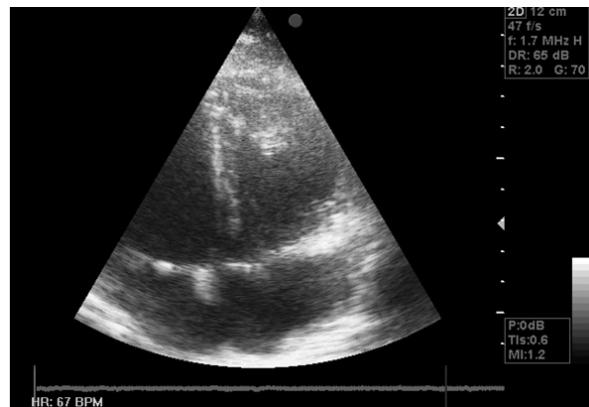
Echocardiographic image of the right ventricular mass.
